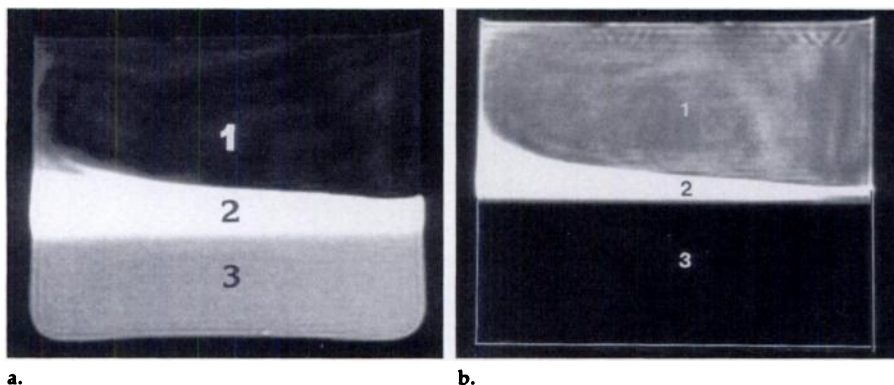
MR images obtained with 600/16 (a) and 2,000/60 (b) sequences show triple-layering phenomenon seen in vivo. Uneven middle "layer" resulted from mixing along edge of container where pipettes were inserted.
